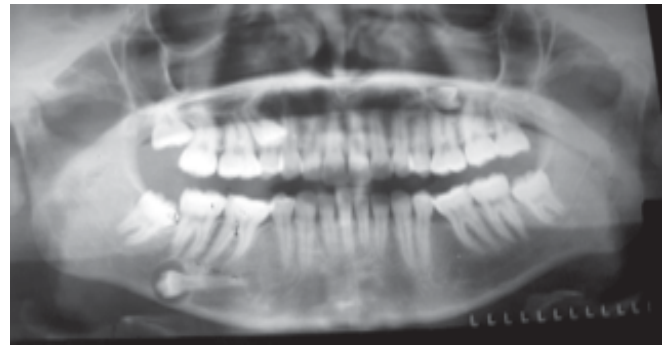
A panoramic radiograph of 20 year female patient shows multiple impacted permanent teeth # 15, 25 and 45 with dentigerous cyst formed around the crown of tooth # 45 leading to thinning of the inferior border of the mandible.
